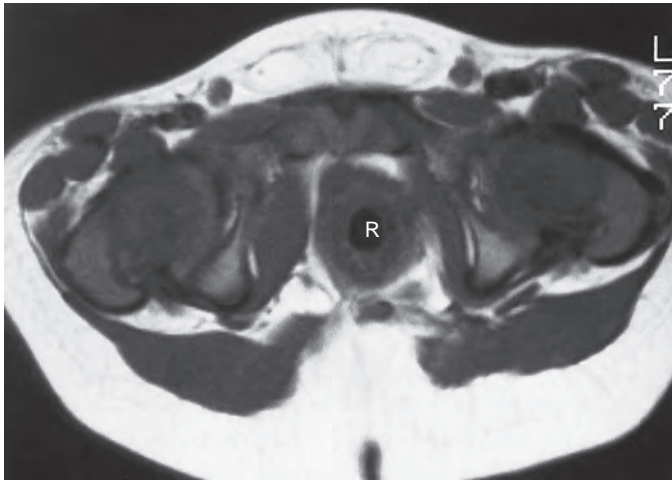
Imperforate anus: MRI of pull-through. Axial MRI shows the anal pull-through in a good position. The rectum (R) is centrally placed within a well-developed sphincteric muscle complex.
